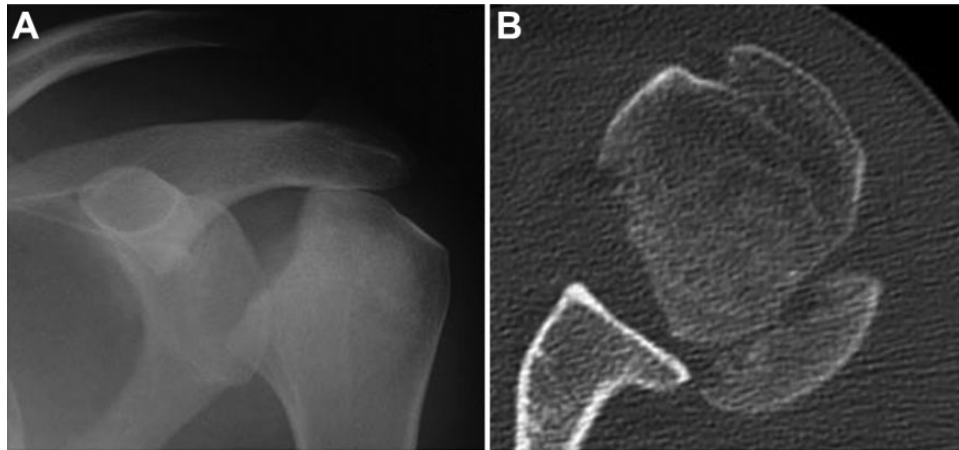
Preoperative (A) radiograph and (B) computed tomography scan.
